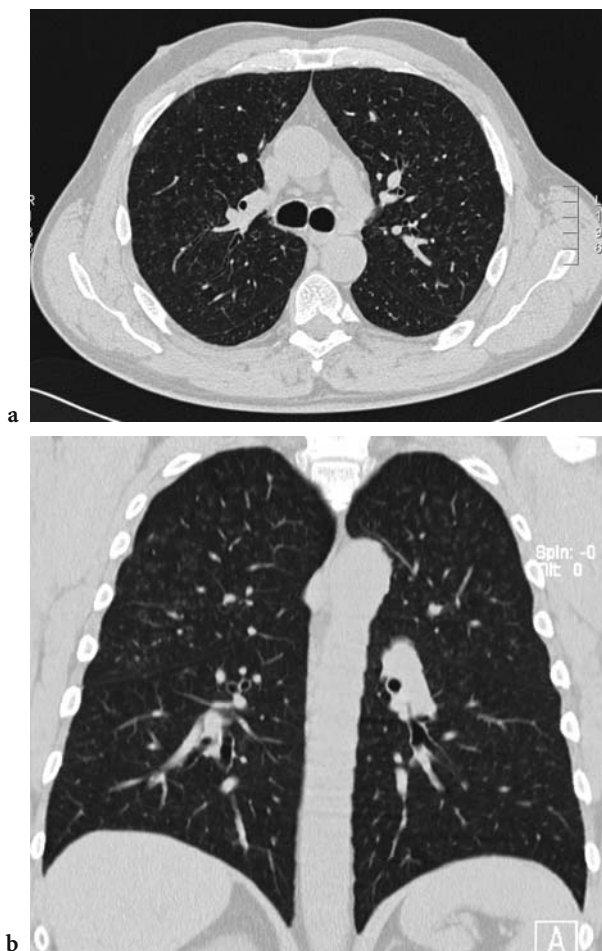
Coal worker's pneumoconiosis: computed tomography scan showing early changes (axial view with slice thickness of 1 mm; coronal reconstruction with slice thickness of 3 mm). Intralobular ill-defined punctuate opacities are seen
